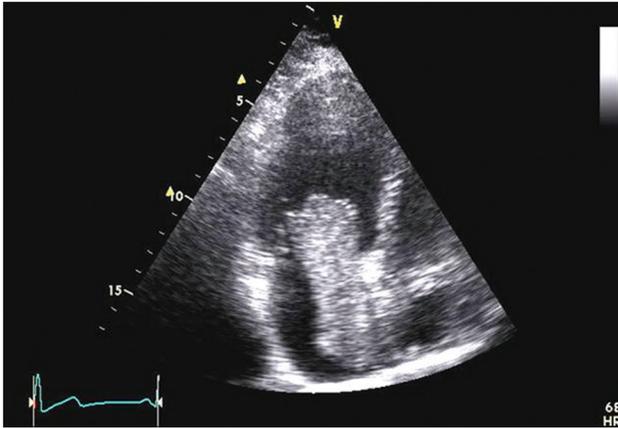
Echocardiography showing a large mass within the left atrium protruding through the mitral valve causing some obstruction to left ventricular inflow
